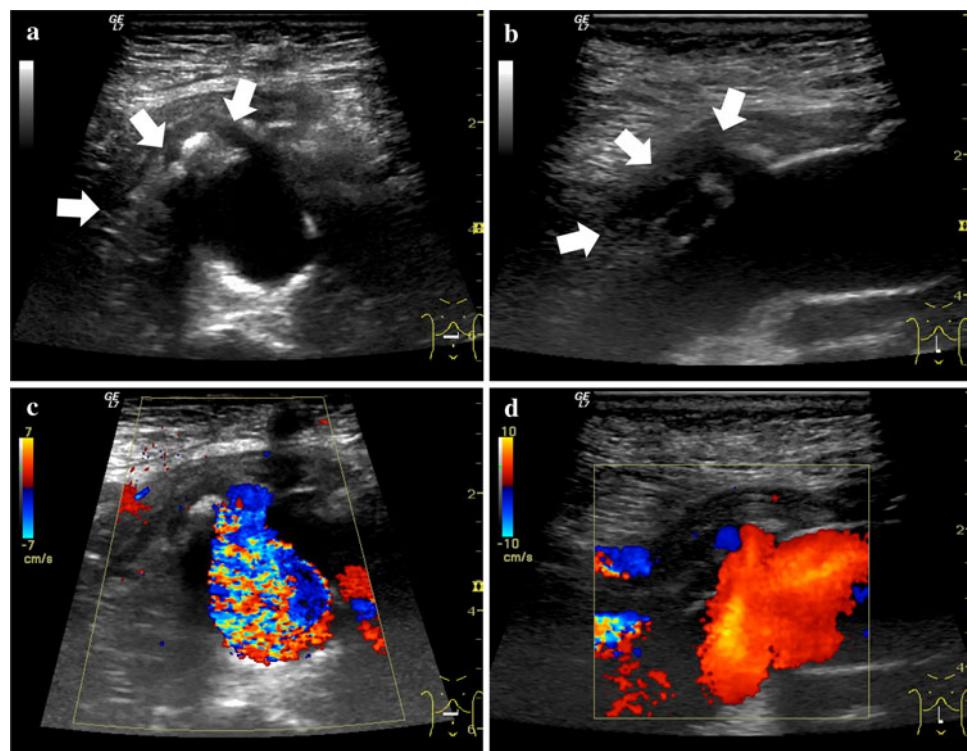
Abdominal ultrasonograms on admission. a Horizontal scan of B-mode ultrasonography. An anechoic lesion (arrows) was detected between the duodenum and aorta. The duodenal wall adjacent to this lesion was thickened, suggesting bleeding from ADF. b Vertical scan of B-mode ultrasonography. Abdominal B-mode ultrasonography demonstrated a 5-mm defect in the vascular wall on the ventral side of the abdominal aorta at the graft anastomosis, and an umbilicated
